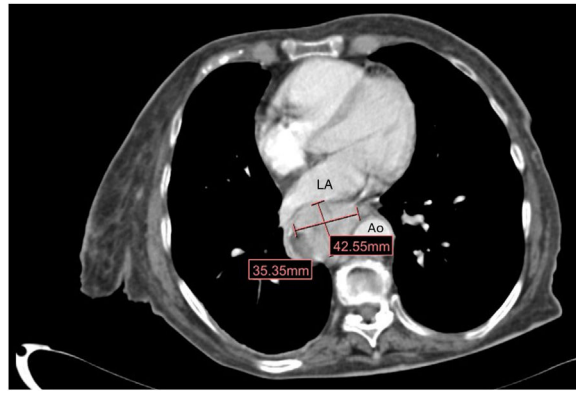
Computed tomography scan with mass in the middle third of the oesophagus middle third of the oesophagus measuring $42 \times 35 \times 55$ cm.
